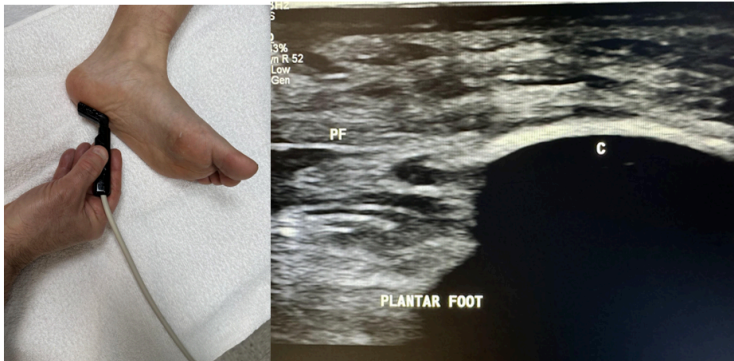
Side-by-side pictures of the transducer position and plantar sagittal view with plantar fascia (PF) insertion into the calcaneus (C). The abbreviations given here and labeled on the ultrasound image represent the corresponding structures.
